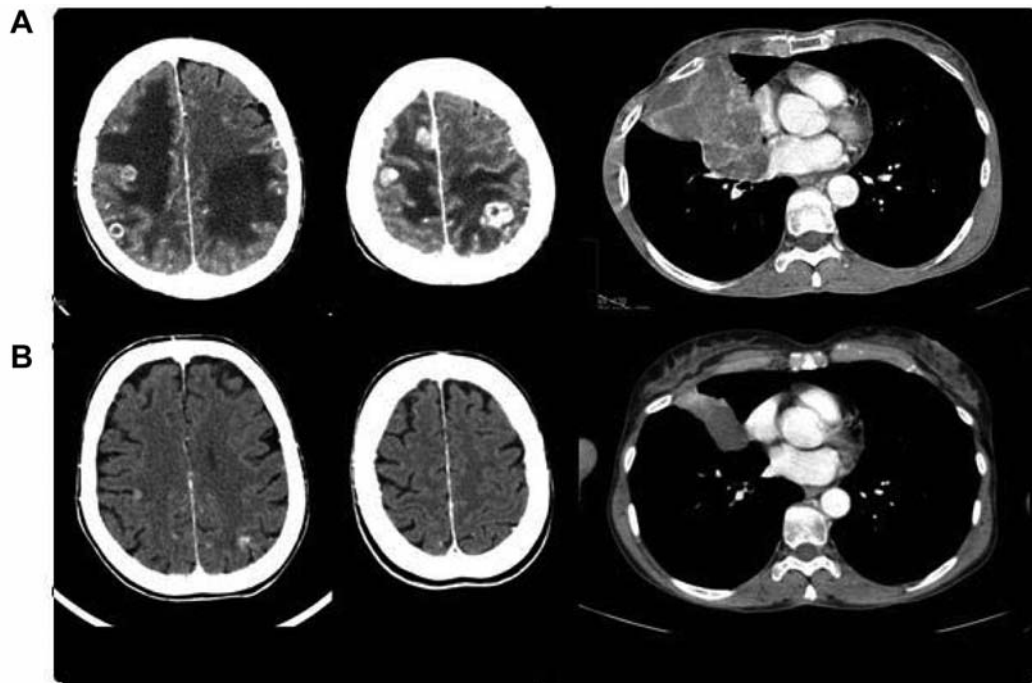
Cerebral and thoracic computed tomography (CT) imaging of a patient with partial response. This patient is a 62-year-old woman with a non-small cell lung cancer with brain metastases. A: Brain metastases with perilesional edema and right pulmonary mass before treatment and B: after the treatment with bevacizumab-based chemotherapy.
